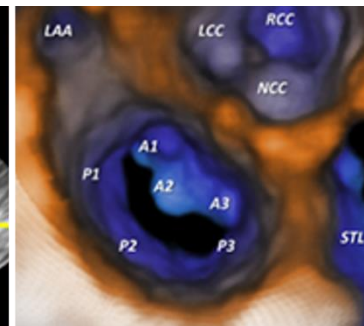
Comparison view of the mitral valve with 2D and 3D echocardiography. (a) Mitral valve structure showing the base of the myocardium with the location of two and four chamber echocardiographic perspectives. (c) 2D echocardiology of the mitral valve can only be seen from the ventricular perspective, with arrows identifying mitral valve between left atrium (yellow) and left ventricle (red). 3D echocardiology allows the mitral valve to be visualised from the ventricular (b) and atrial (d) perspectives. Where the mitral valves anterior and posterior leaflet identified, with the latter having more visual indentations (scallops) which are numbered from anterolateral to posteromedial into P1, P2, and P3, and the anterior leaflet numbered corresponding to the posterior into A1, A2 and A3. Adapted from (European Society of Cardiology, 2022).
